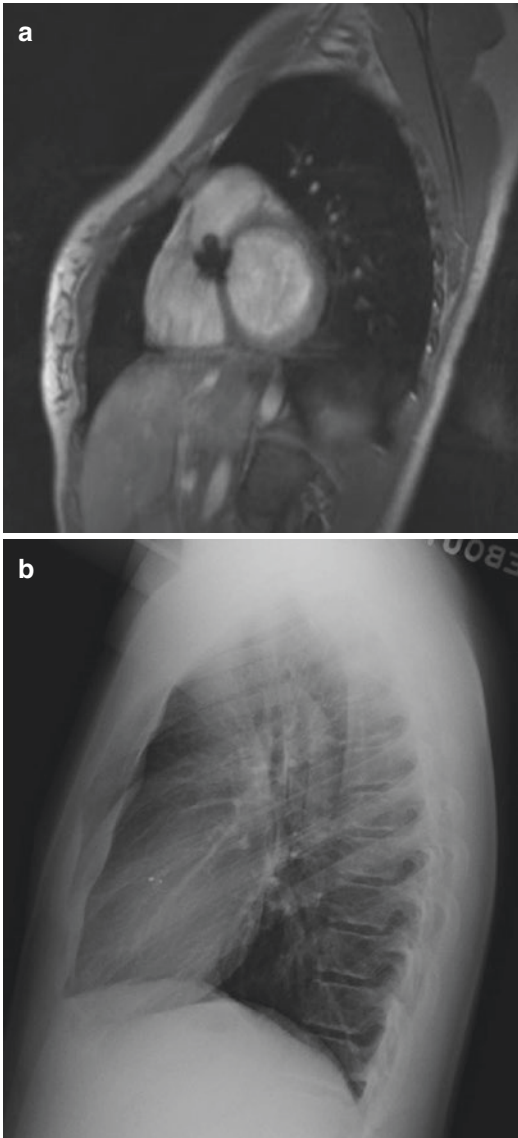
(a) Short-axis view (*left*) and (b) lateral chest X-ray (*right*) in a patient with a perimembranous VSD treated with a septal occluder device
